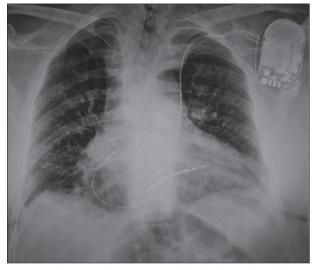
Chest X-ray demonstrating dual-chamber implantable cardioverter defibrillator implanted through persistent left superior vena cava
